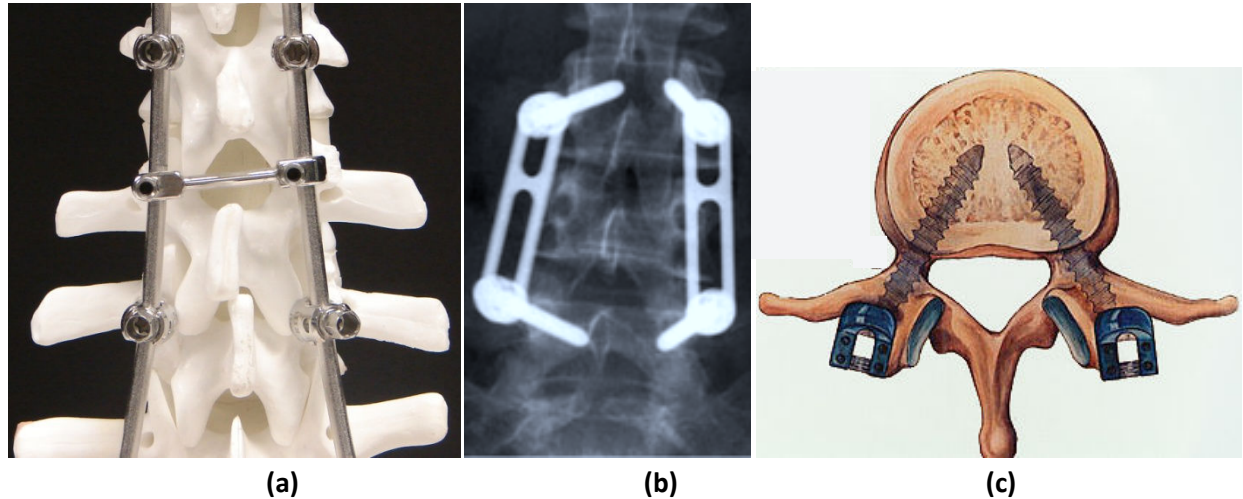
Posterior lumbar fusion instrumentation. (a) Posterior view of a pedicle screw-rod fixation system affixed to a spine model. (b) Posterior x-ray of pedicle screws connected to a plate system spanning two levels in the lumbar spine.⁴⁸ Reprinted from Rutherford et al., 2007 with permission from King, L and the Radiological Society of North America. (c) Axial view of a lumbar vertebra with pedicle screws inserted.⁴⁹ Reprinted from Foley et al., 2001 with permission from MedScape.com, 2010.
